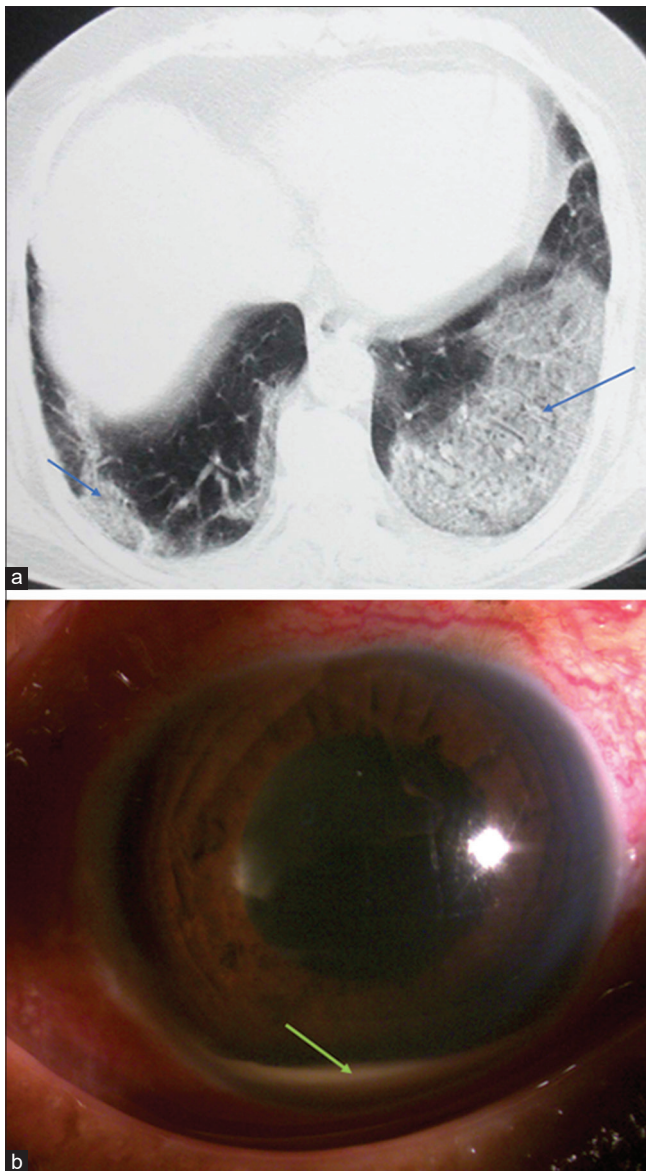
(a) CECT thorax scan images showing ground glass opacities (blue arrow) with interstitial thickening bilaterally with CT severity score of 15/25 and CO-RADS grade 5; (b) Anterior segment slit lamp photograph showing congestion with few Descemet membrane folds, fibrin in pupillary region, inferior hypopyon (green arrow) with an IOL *in situ*
